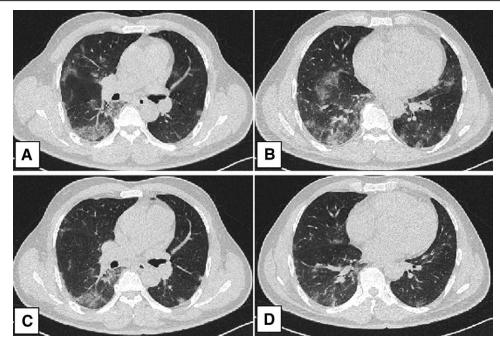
Case 1. On the second day of admission (6 days after onset), chest computed tomography demonstrated patchy and nodular ground-glass opacities and consolidation and linear opacities in the bilateral lungs, mainly in both lower lungs (A, B). The lung lesions were greatly absorbed at 70 h after the plasma treatment (C, D).
